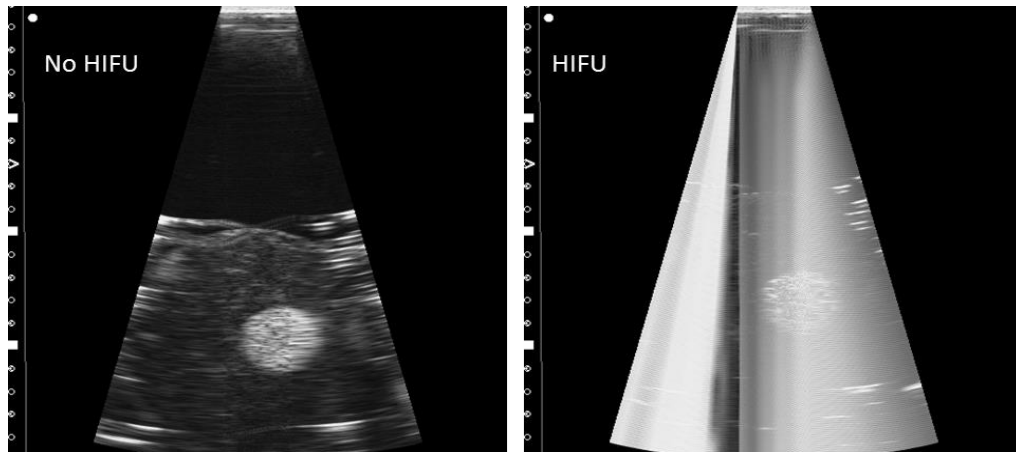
Diagnostic ultrasound image quality changes a lot with and without HIFU interference. The target area (round white area) cannot be recognized when HIFU is switched on.
